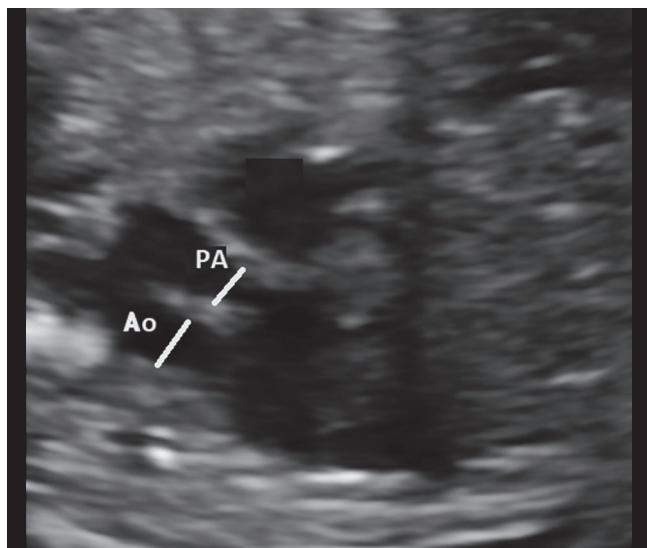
The fetal cardiac ultrasound in the sagittal view of the great vessels shows the anterior Ao, the PA, and the smaller pulmonary annulus, indicating pulmonary stenosis.
